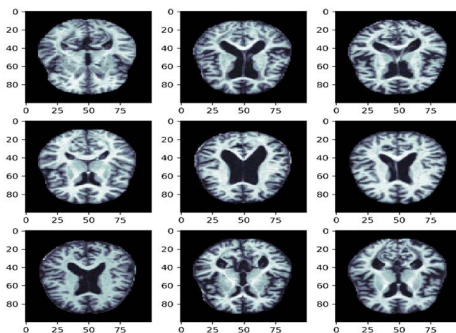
Unhealthy brain MRI images with tumor.
